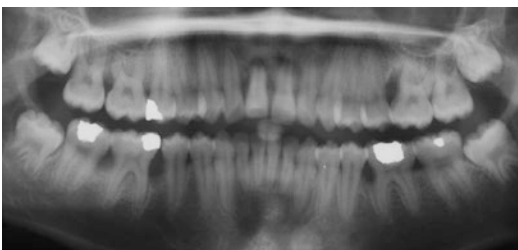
Panoramic radiograph of patient shown in Fig. 7.1. Please note localized alveolar bone loss affecting mainly upper right central incisor and first molars
